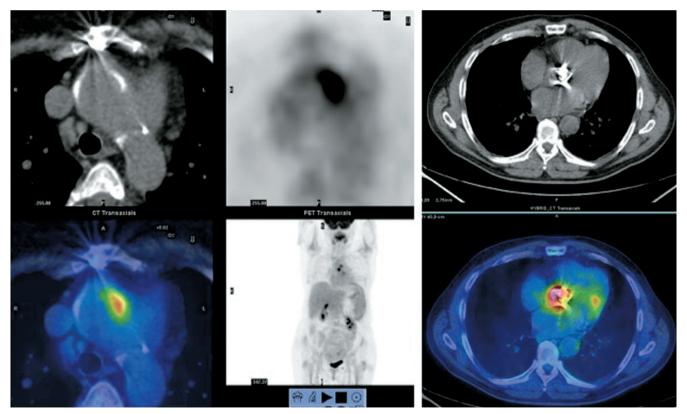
[18F]FDG PET/CT in infection of the aortic arc and of the valvular prosthesis without involvement of the sternum.
